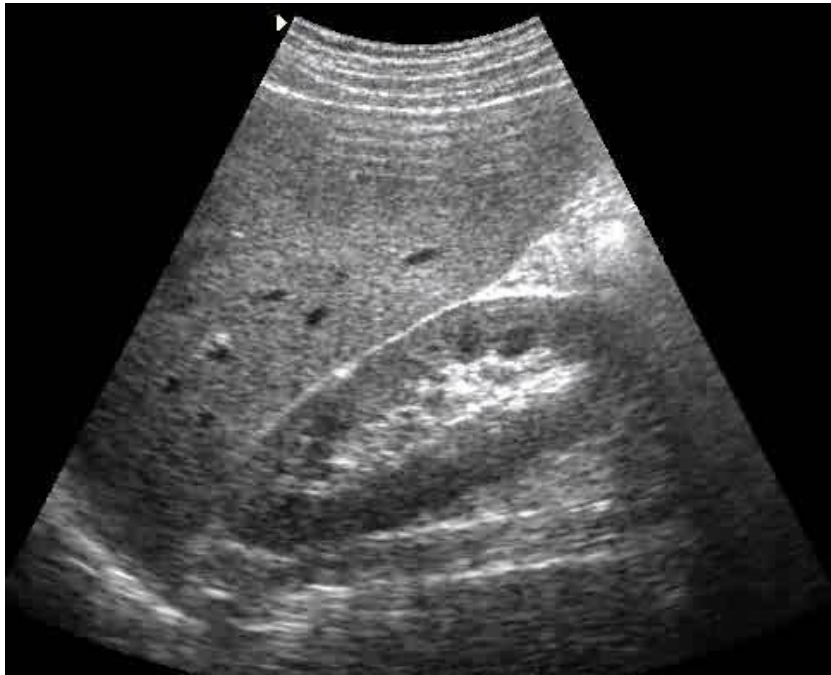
Sonographic appearance of normal right kidney.
